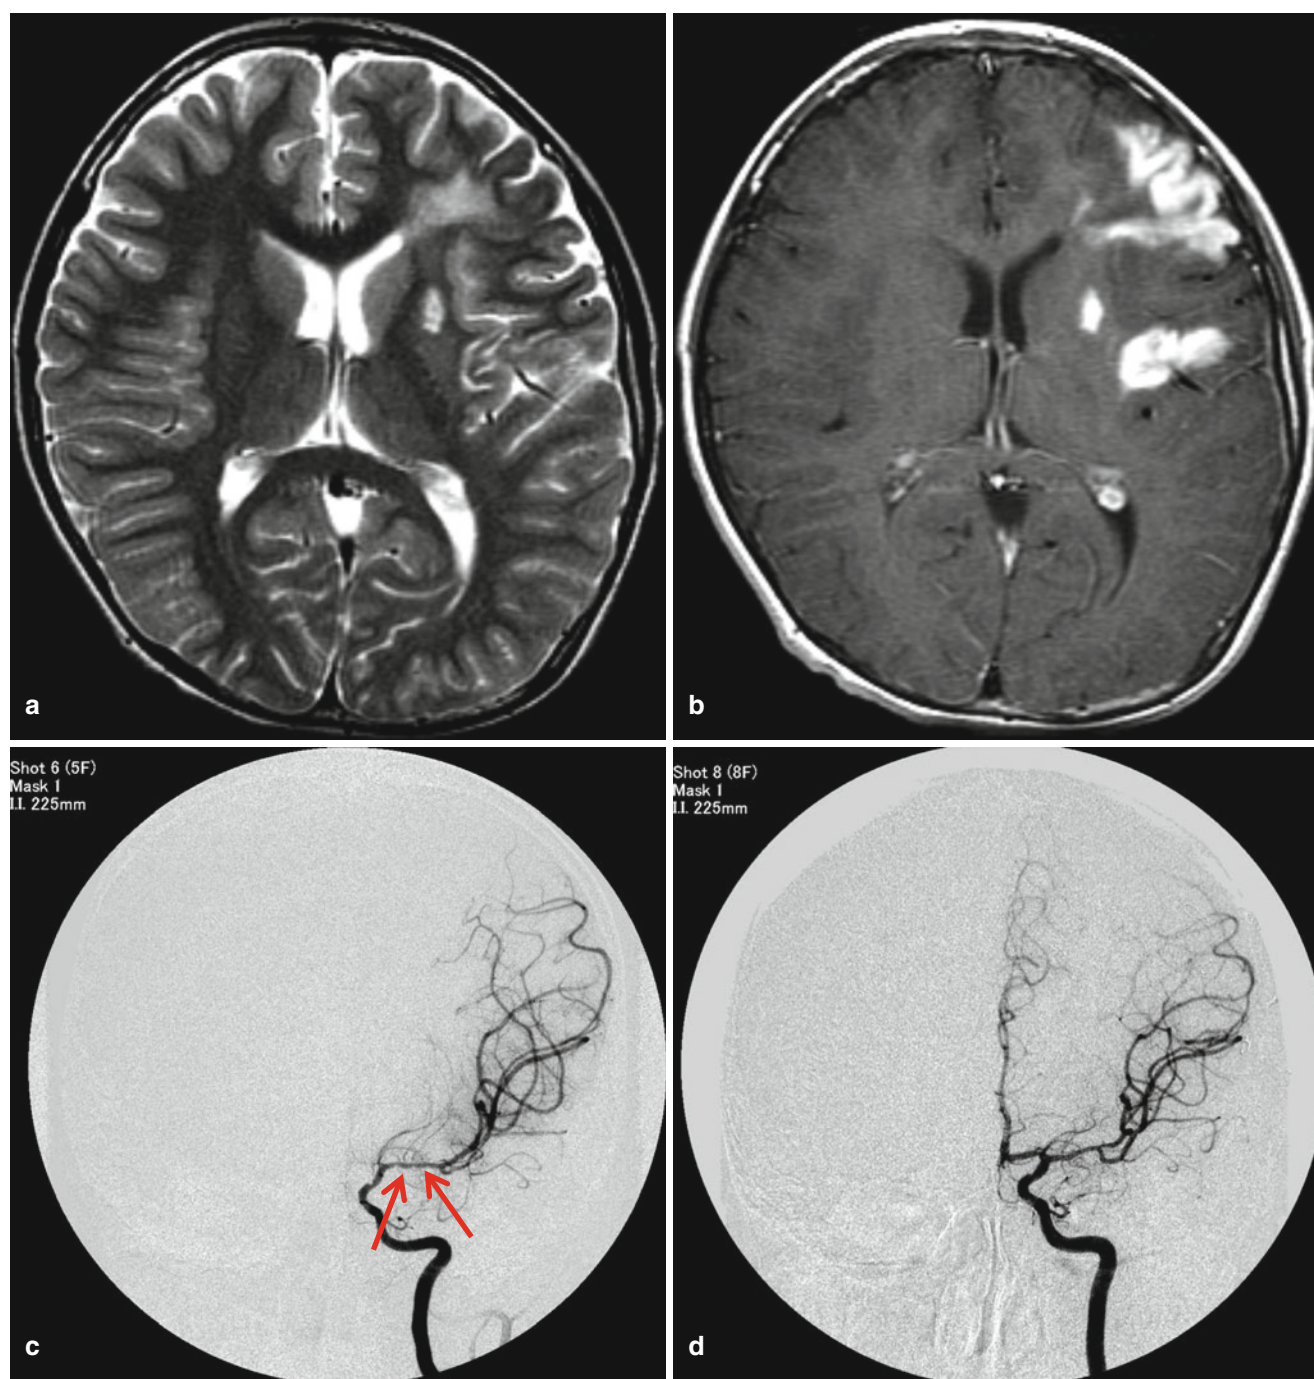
An 8-month-old boy with right-side weakness suspecting post-viral angiitis. (a) T2-weighted image shows high signals in the left frontotemporal lobe and putamen. (b) Gyriform enhancement of the frontotemporal lesion and putamen suggests infarction. (c) Left distal
